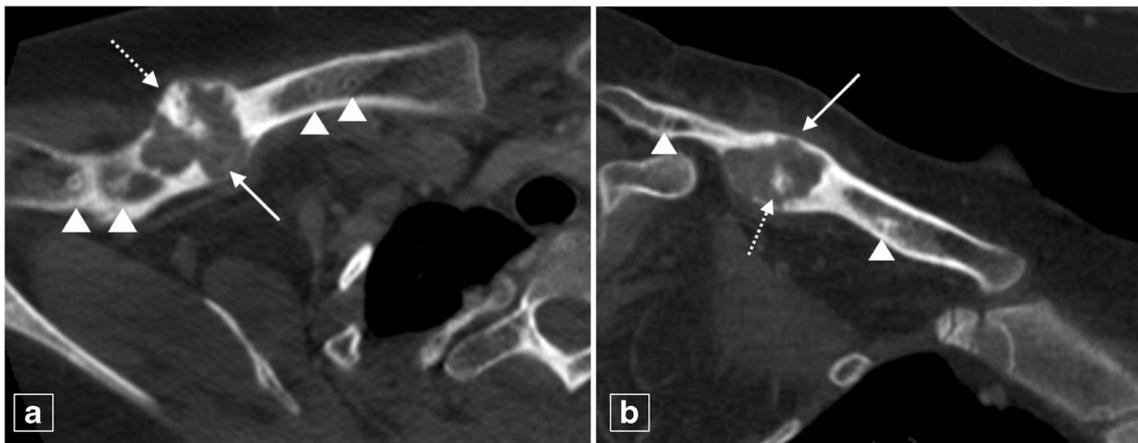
Axial (a) and coronal (b) reformats of a chest CT, which included the clavicle 5 years after the initial trauma showing a well-defined expansile lytic lesion (solid arrows) with small foci of internal osteoid
